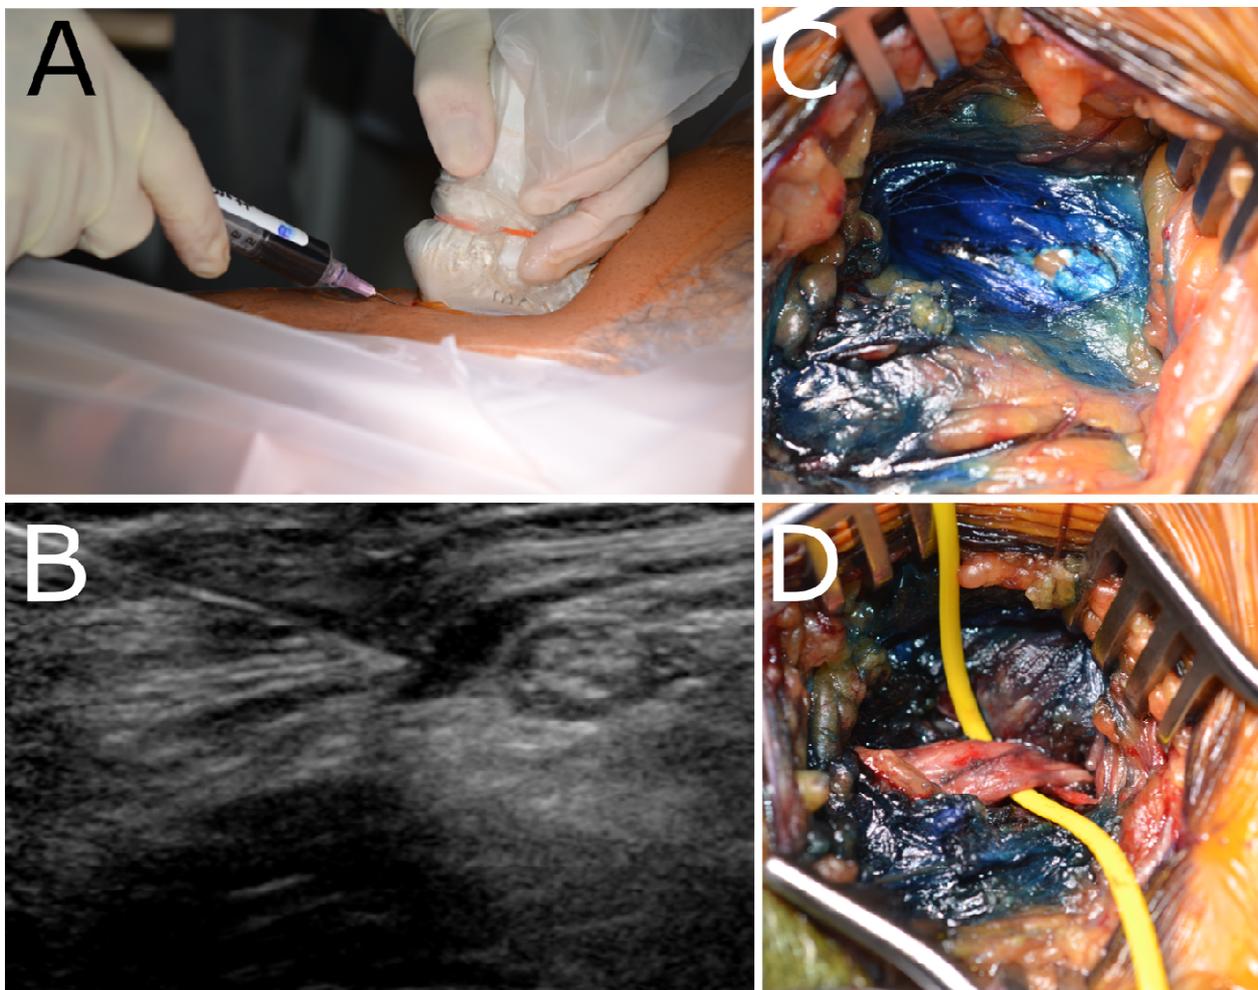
Ultrasound-guided methylene blue injection for peripheral nerve localization. Using ultrasound guidance, methylene blue was injected immediately proximal to the site of an enlarged lateral femoral cutaneous nerve (A and B). This allowed for rapid dissection to immediately proximal to the affected nerve (C), followed by careful dissection to access the nerve (D).
